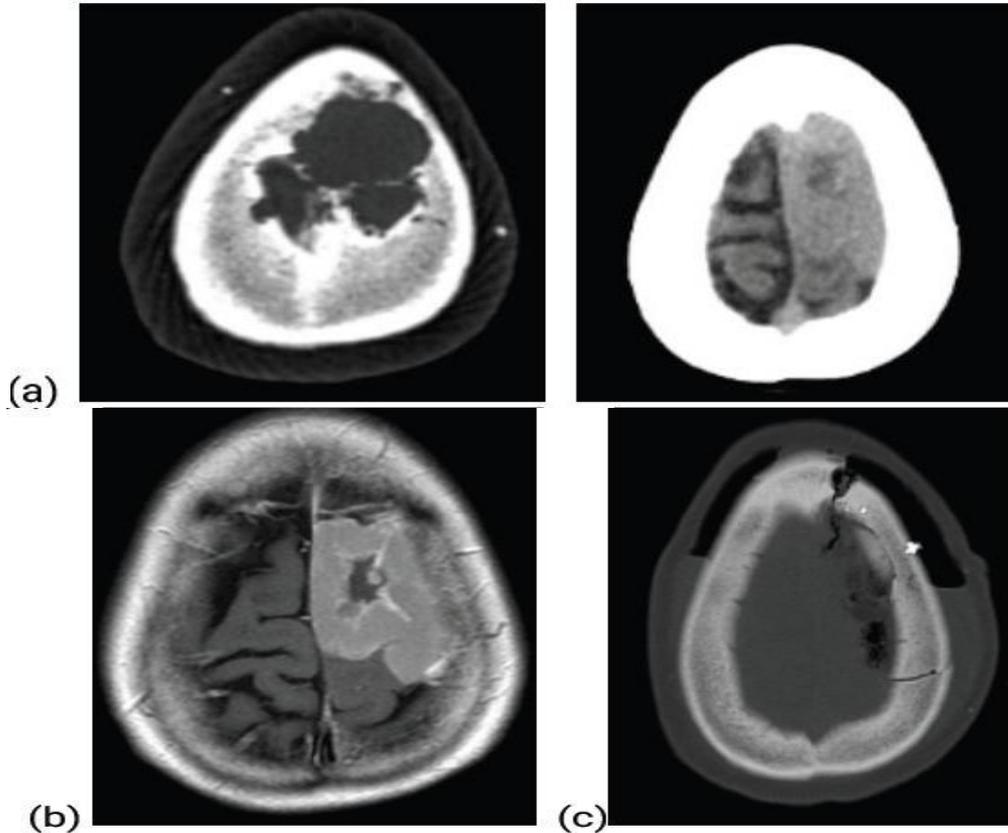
Meningioma (Grade II). (a) preoperative CT-scan bone and brain window axial image shows left frontal high convexity intra diploic, expansile, lytic lesions with great hyperostosis as well as eroded inner table. (b) preoperative post-contrast T1WI-MRI shows enhanced extraaxial mass with dural-based dural tails. (c) postoperative axial head CT images bone window after reconstruction of the skull.
